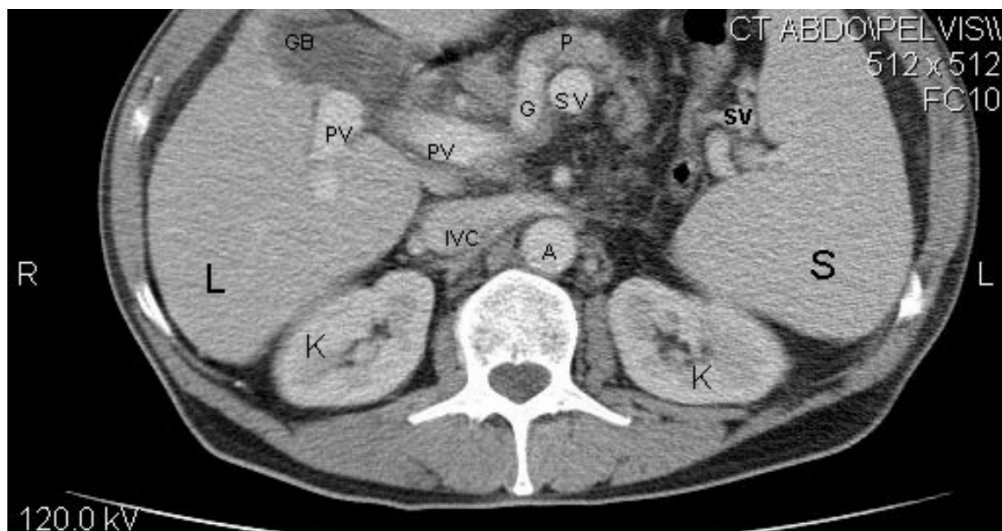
Transverse abdominal CT scan with intravenous contrast of patient EPP8.2 showing features of portal hypertension. Note the splenomegaly, the dilated portal and splenic veins, and the abnormal gallbladder. Ascites is not apparent, as the images were taken after paracentesis. (L = liver, S = spleen, K = kidney, A = aorta, IVC = inferior vena cava, PV = portal vein, SV = splenic vein, G = left gastric vein, P = pancreatic neck vein). Courtesy of Prof S Benningfield, Department of Radiology, UCT and GSH.
